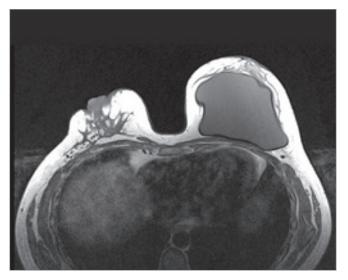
Magnetic resonance imaging. In the left breast, there is evidence of a prepectoral implant without signs of rupture, and in the right breast, there is heterogeneous fibroglandular tissue and nipple retraction.
